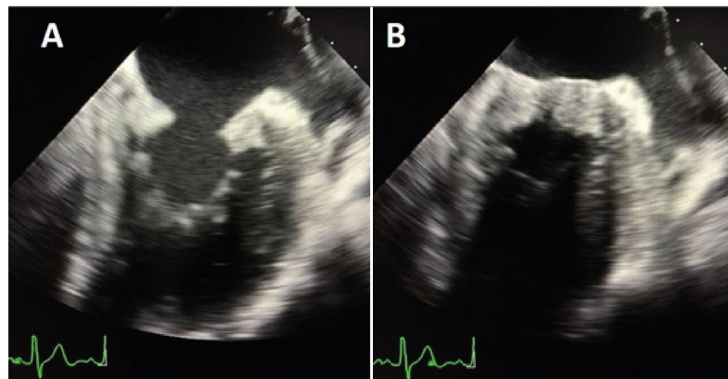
Two-chamber transesophageal echocardiography at 90° demonstrating diffuse thickening of mitral valve leaflets in diastole (A) and systole (B).
